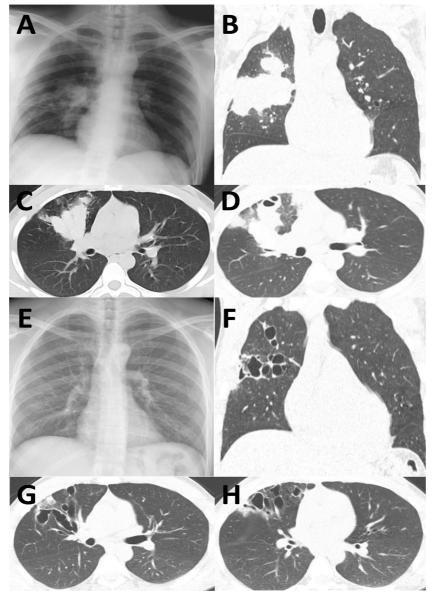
Comparison of chest X-ray and CT at admission (A-D, a 6 cm-long right hilar mass is observed, extending to the pleura and enlarged hilar lymph nodes) and 4 months after disease resolution (E-H, large varicoid bronchiectasis in both lungs can be observed, particularly in the right upper lobe.).
